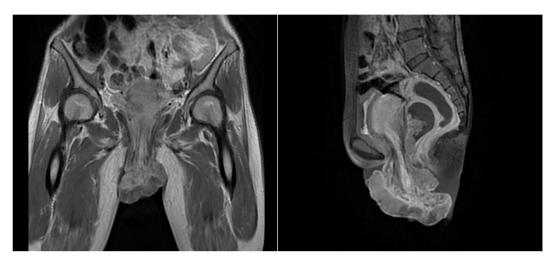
Pelvic MRI with mass enhanced after contrast injection.
